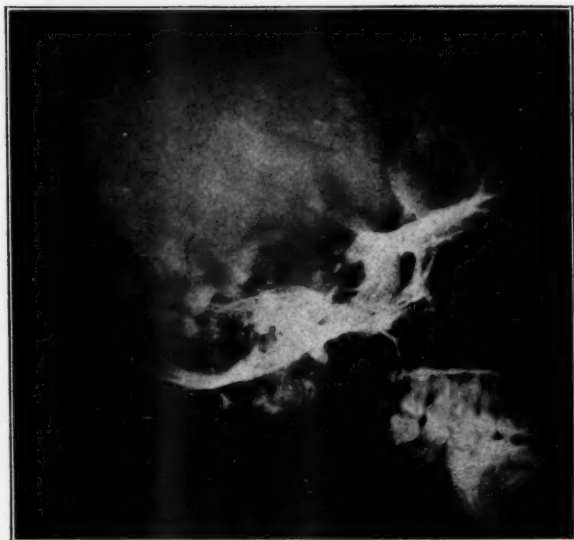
(case 5).—Roentgenogram of the skull, showing increased density of the greater and lesser wings of the left sphenoid bone, due to thickening of these structures.
